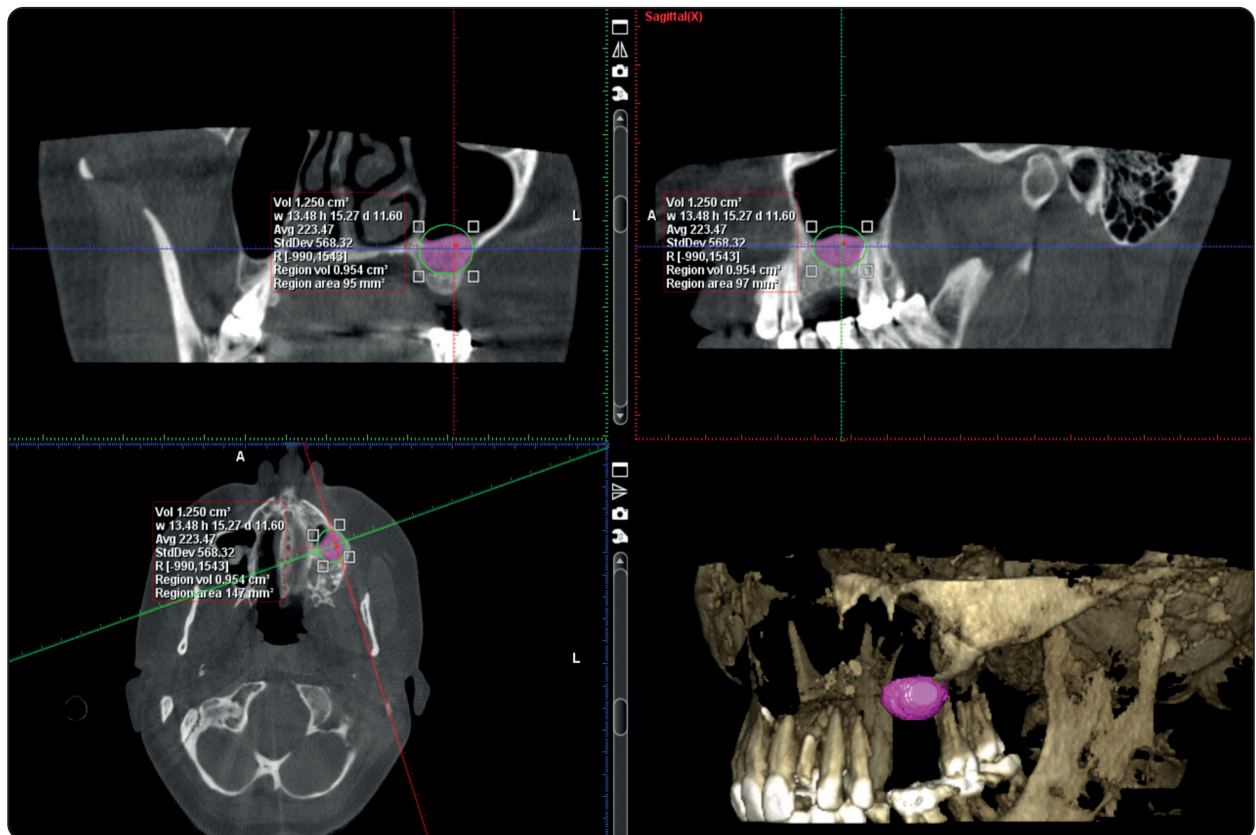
CBCT images revealing volumetric assessment of the graft using Planmeca Romexis viewer 4.6.0.R: Reformatted Coronal, sagittal and axial sections and 3D volume rendered image revealing the automatic segmentation of the bone graft with manual adjustments to include all the graft. The region volume was counted as the graft volume.
